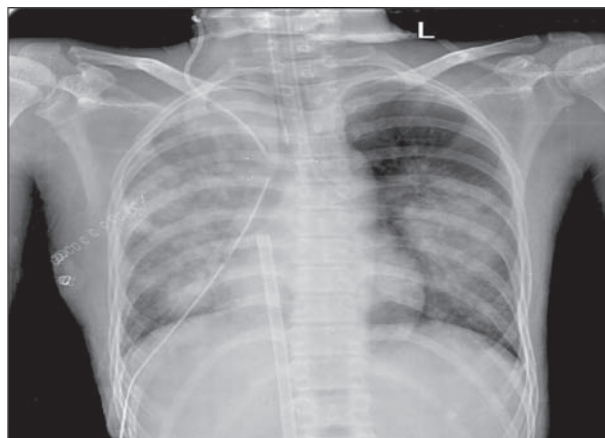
Post-ECMO chest x-ray demonstrating pulmonary edema.
